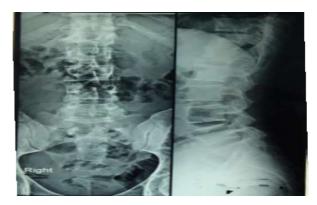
Lumbosacral Spine X-ray (AP and Lateral View) showing reduced disc space between D 11 and 12 (Pott's Spine)
